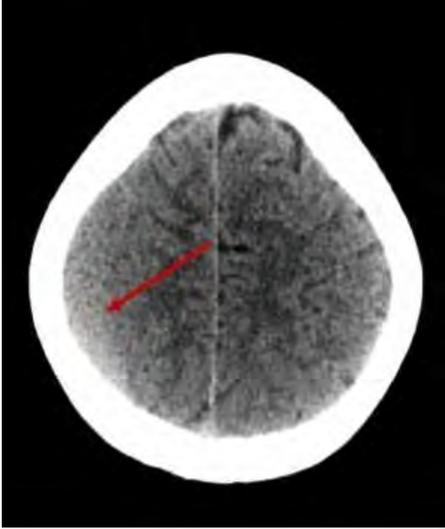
CT brain showing acute blood layering in chronic subdural collection
